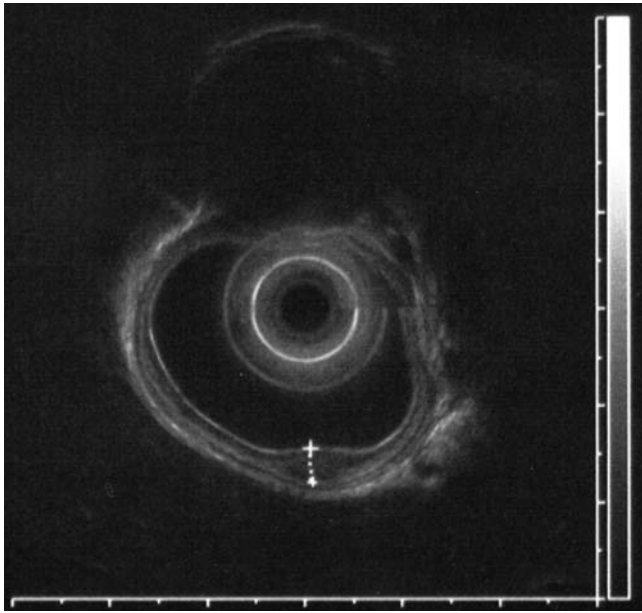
Endoscopic ultrasound (EUS) picture of an early tumor confined to the mucosa. Five layers of the esophagus could be seen; the two dark layers are the muscularis mucosae (inner layer) and muscularis propria (outer layer). In this tumor, the hyperechoic layer of the submucosa has not been reached. The tumor is at 6 o'clock. This lesion was removed with endoscopic submucosal dissection (ESD) technique.
